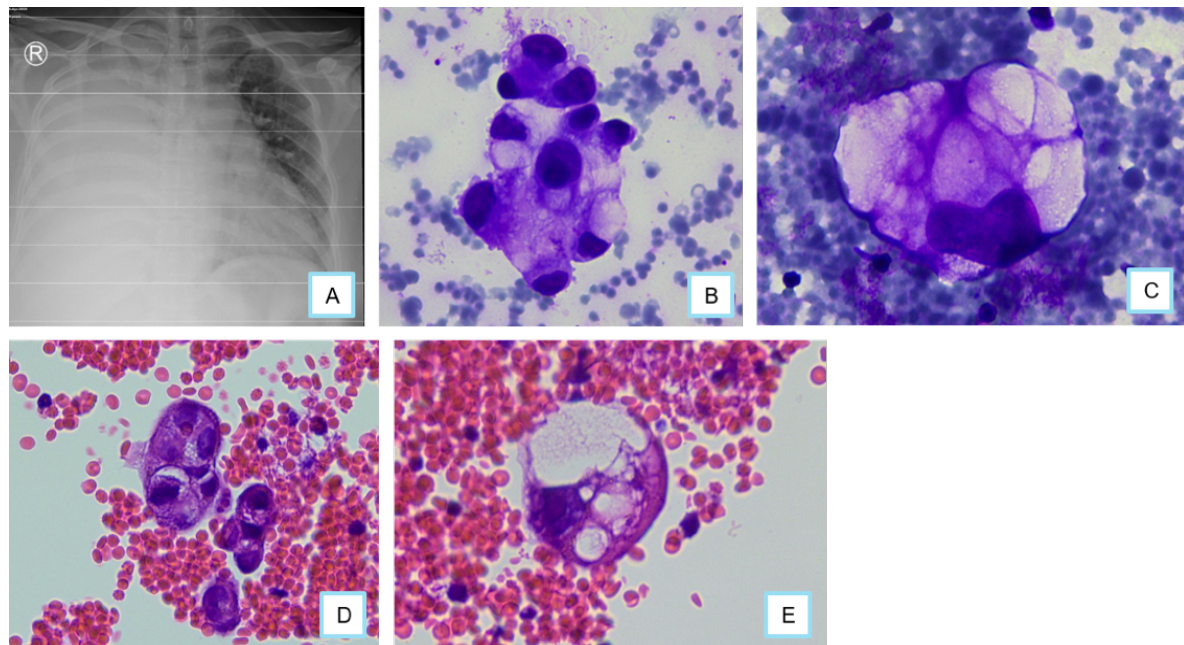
(A) Thoracic X-ray showing coarse hila with an increased bronchovascular pattern and homogeneous right upper and lower infiltrates. (B) Cluster pattern on the conventional smear (400x, Giemsa). (C) Predominant single-cell pattern on the conventional smear (400x, Giemsa). (D-E) Single-cell and vague glandular-like patterns on the cell block of pleural fluid.
